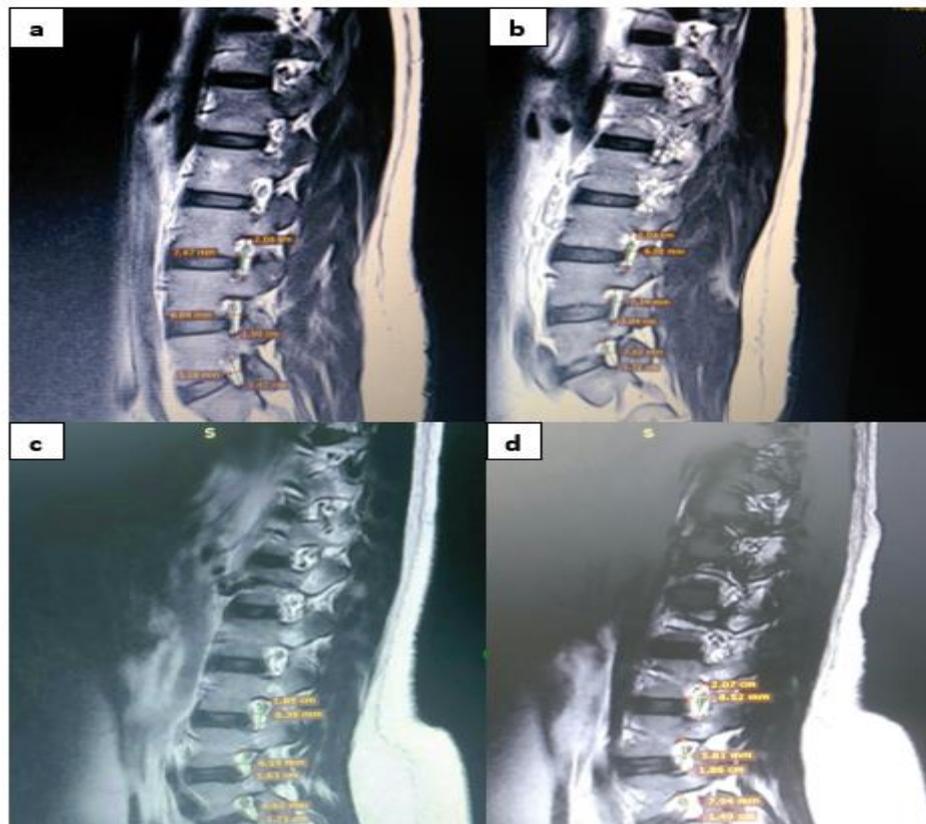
T2 MRI image showing lower three lumbar inter vertebral foramina (IVF) measurements in 33 years old male and 33 years old female; (a,c) right side, (b,d) left side respectively.
